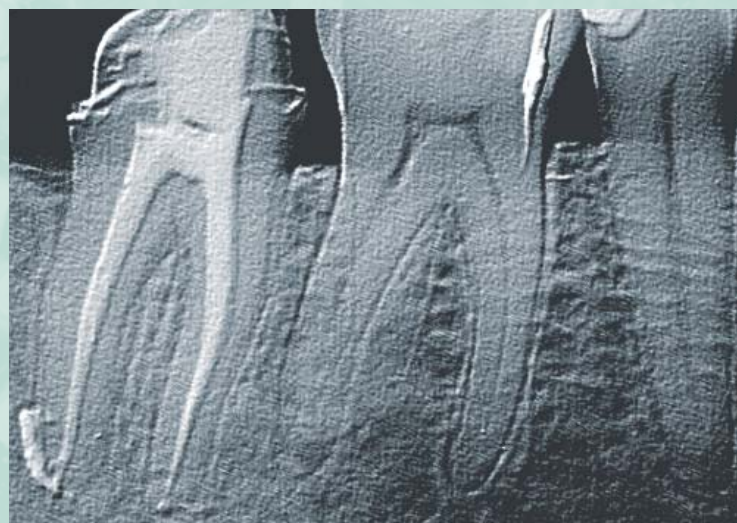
Six-month recall radiograph shows complete healing. The tooth was immediately provisionalized with an acrylic crown after endodontic therapy and is now asymptomatic.
